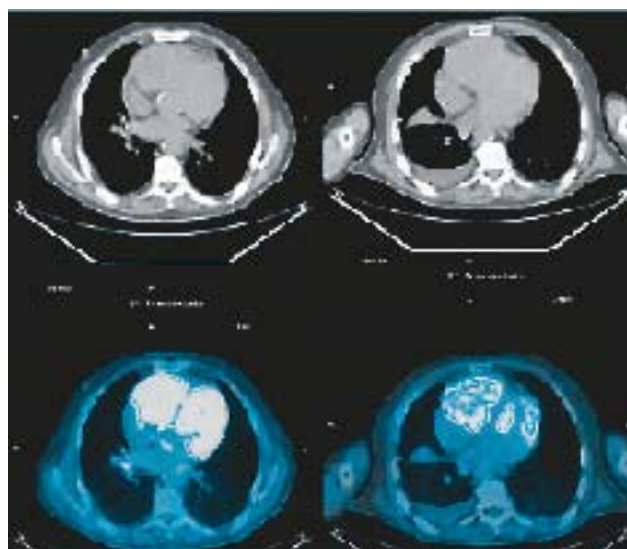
The ^{18}F -FDG-PET/CT scan shows high uptake at the right ventricular mass before treatment and after 4 cycles of ^{90}Y -Dotatoc.
